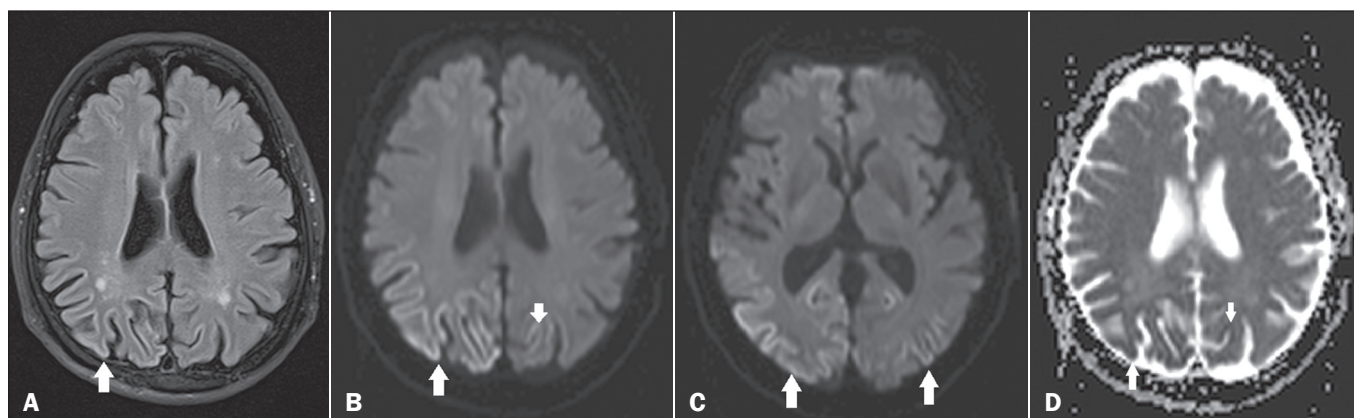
A: Axial FLAIR MRI sequence showing a hyperintense signal in the bilateral parieto-occipital cortex (arrow), more evident on the right, sparing the subcortical white matter. B: Axial diffusion-weighted MRI, at the level of the basal ganglia and thalami, showing no changes in signal intensity. Note the restricted diffusion in the bilateral parieto-occipital cortex (arrows). C: Axial diffusion-weighted MRI, at the level of the basal ganglia and thalami, showing no changes in signal intensity. Note the restricted diffusion in the bilateral parieto-occipital cortex (arrows). D: Axial MRI, with apparent diffusion coefficient mapping, at the levels depicted in A and B, showing low signal intensity, confirming the restricted diffusion, in the cortical lesions.
